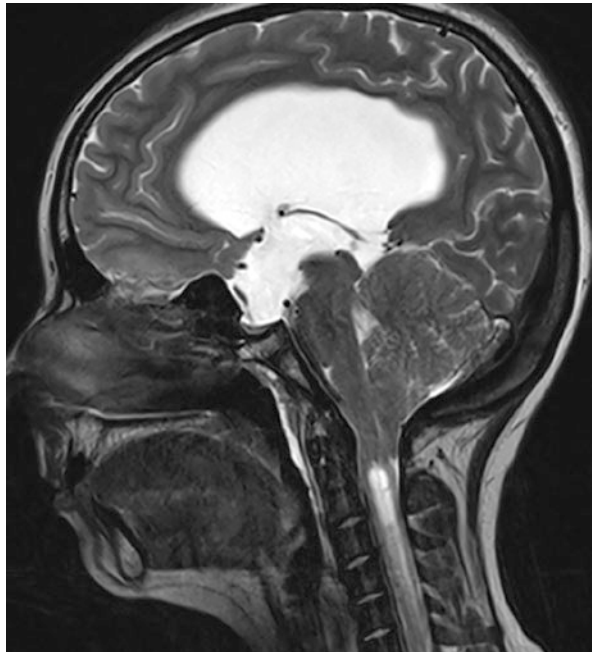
MRI of 10-year-old Chiari type I malformation patient showing on sagittal T2 brain MRI (right image) tonsillar ectopia and cervico-thoracic syringomyelia. Simultaneously on sagittal (left image) and axial (middle image) T1 “fat sat” lumbar MRI signs of tethered cord syndrome with a low-lying conus and fatty filum (red arrow) at the level of L2/L3
